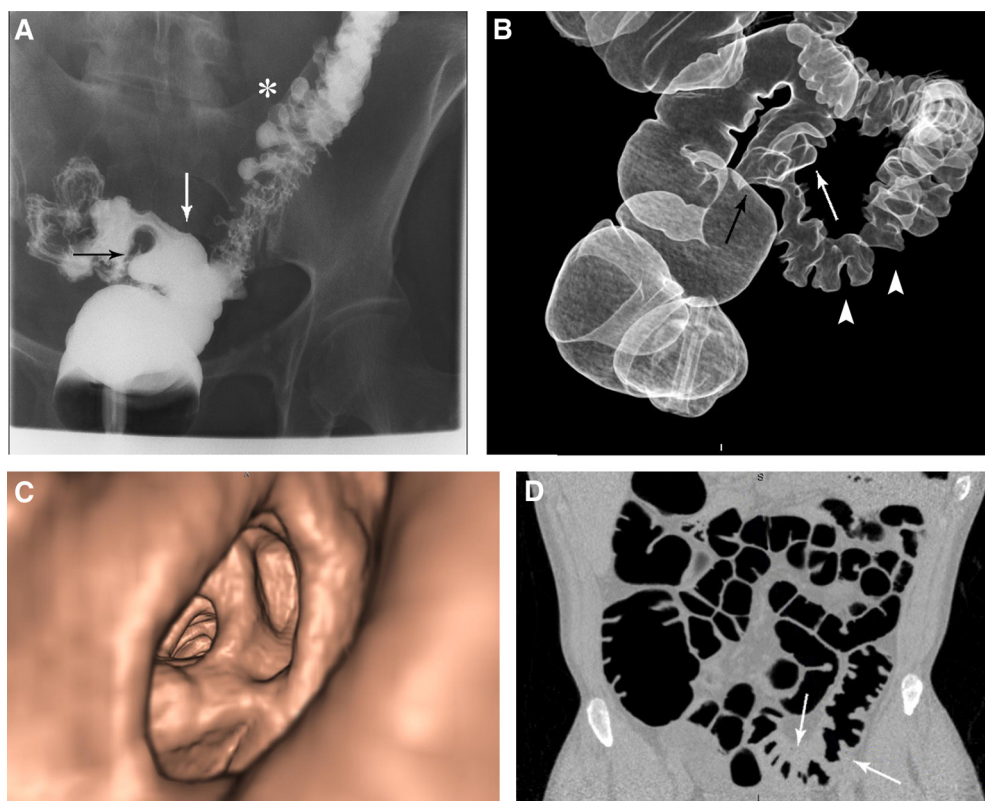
Chronic diverticular disease complicated by sigmoid stricture. Double-contrast barium enema image in a 76-year-old male patient (A) shows a long region of luminal narrowing of the sigmoid colon, associated with severe diverticular disease (asterisk). Unlike malignant or Crohn's strictures, the mucosal surface appears intact. However, margins can be abrupt and shouldered (arrows), as with malignant lesions. Three-dimensional scout computed tomography (CTC) image (B) from a 52-year-old male patient demonstrates a similar long diverticular stricture, with intact mucosa, shouldered margin (arrows), and thickened haustral folds (arrowheads). Endoluminal CTC virtual endoscopy view (C) from the same patient demonstrates a distorted but grossly intact mucosal surface, corresponding with the strictured region of bowel. Cross-sectional CTC coronal view (D) shows mucosal thickening (arrows) and persistent diverticula.
